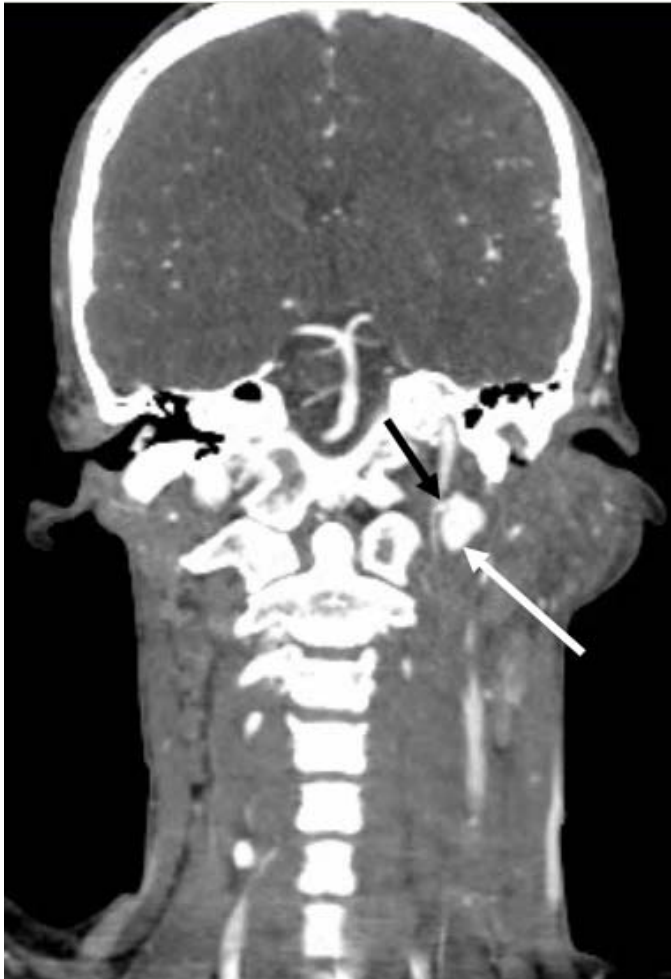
Coronal reformatted image of CT Angiogram demonstrating Internal Carotid Pseudoaneurysm (white arrow) and neck (black arrow). Note the soft tissue swelling of left sub-auricular region of neck from bleeding.
